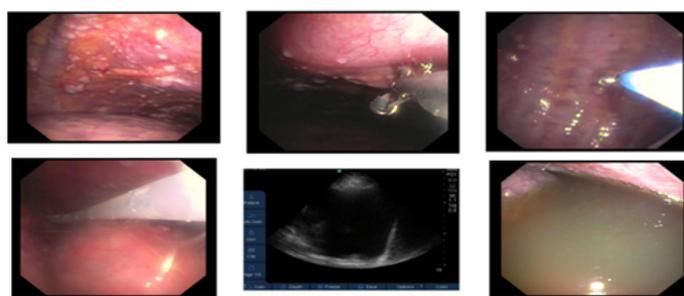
Medical pleuroscopy with parietal pleural biopsy and tunneled pleural catheter placement. Top left image: View of the pleural space showing multiple nodules on the parietal pleura. Top center and right images: Forceps biopsy with direct visualization via pleuroscope. Bottom right image: View of the pleural space showing pleural fluid before complete drainage. Bottom center image: Ultrasound image of the pleural fluid before pleuroscopy. Bottom left image: View of the inserted pleural catheter at the end of the pleuroscopy.
